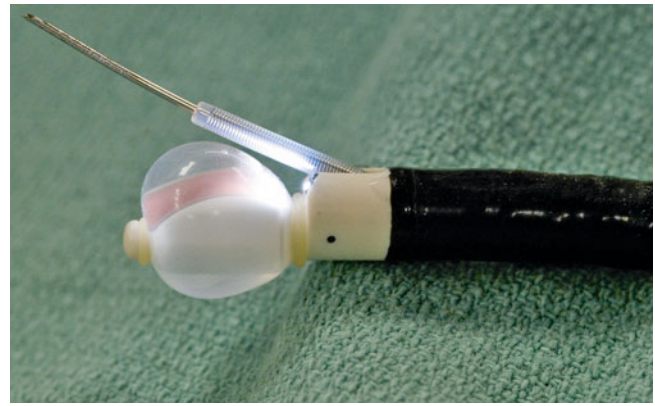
The linear endobronchial ultrasound scope (Olympus Corp, BF-UC180F). The curvilinear ultrasound probe is covered with a saline-filled balloon to aid acoustic coupling with the tracheal wall. A 22-gauge needle and sheath exits the bronchoscope at 30° off-axis
